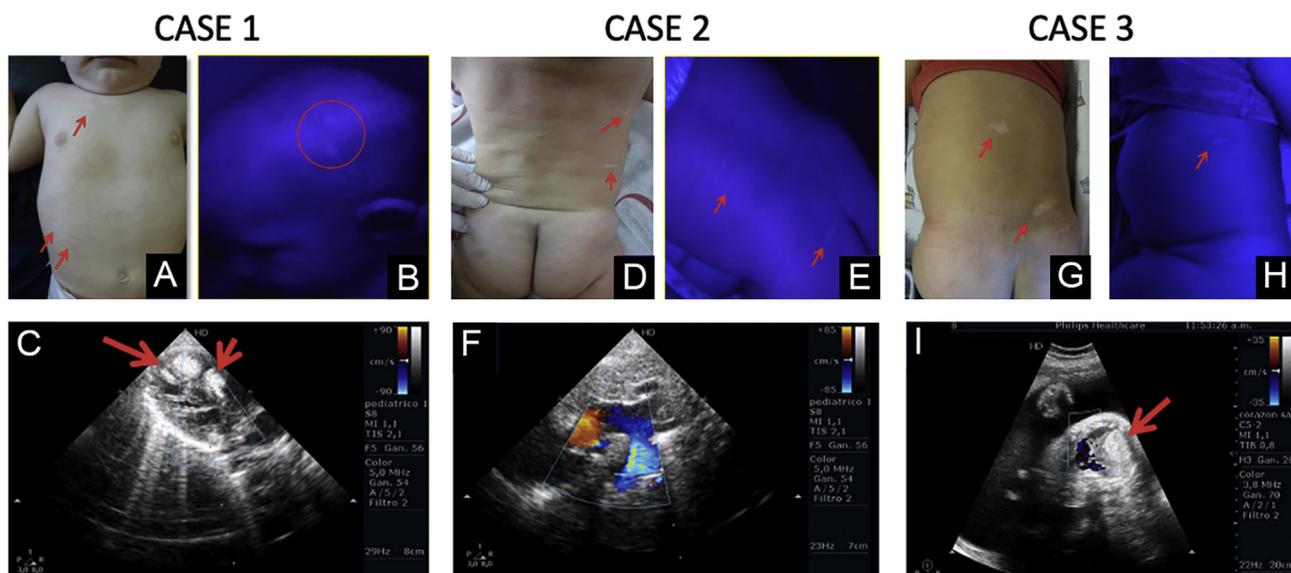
(A-I) Clinical images at physical examination, under Wood's lamp and sonographic imaging of cardiac rhabdomyomas of each case
